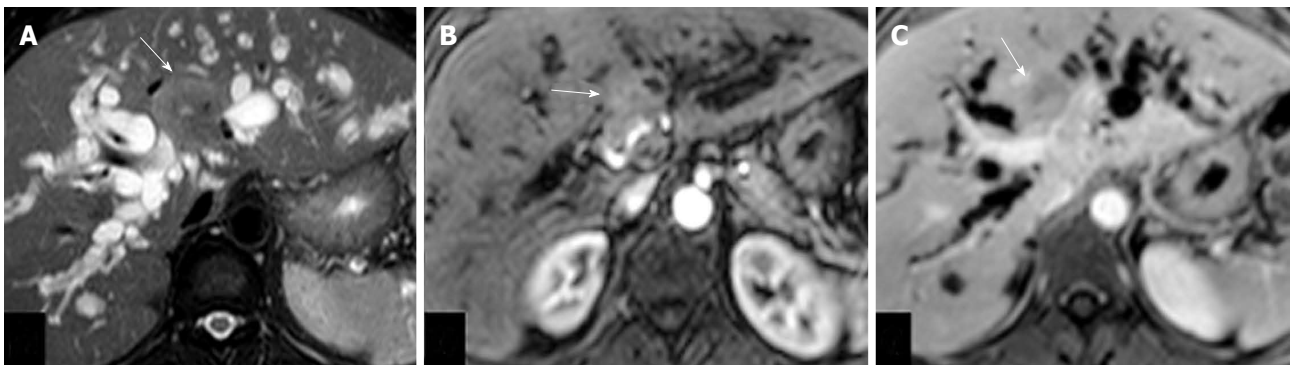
Case of nodule type of hilar cholangiocarcinoma. A: Axial T2-weighted magnetic resonance image show hypointense hilar mass (arrow) with biliary dilatation; B and C: Axial T1-weighted magnetic resonance images in arterial (B) and venous (C) phases showing mildly enhancing ill-defined mass lesion (arrow) encasing right hepatic artery and left portal vein.
